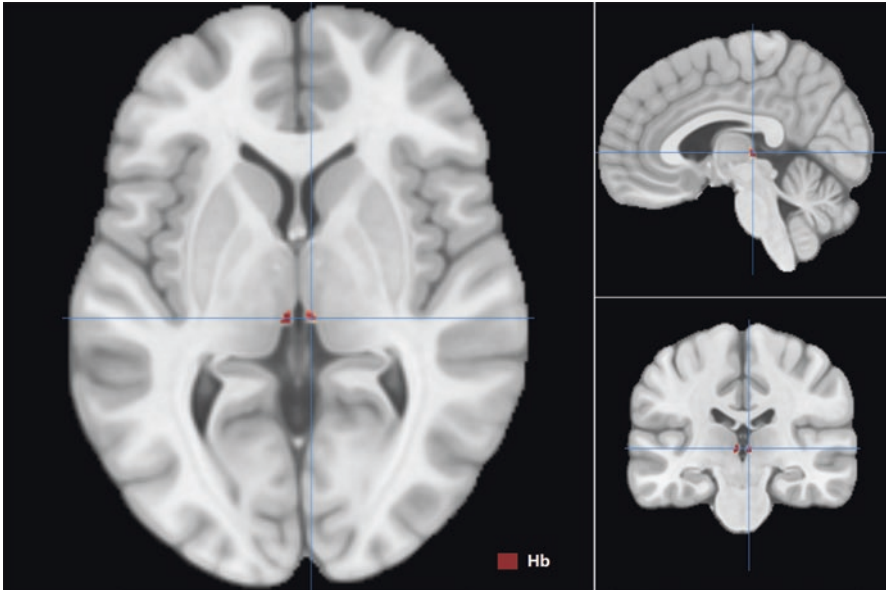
The red marker on the MRI image shows the anatomical location of Hb. It locates in the iliac triangle at the head of the pineal gland and inside the dorsal thalamus. Hb can be divided into medial habenula and lateral habenula. The content of myelin in Hb is high, so it can show a high signal intensity in T1-weighted imaging. Hb shows an obvious boundary with the surrounding tissues and cerebrospinal fluid space
